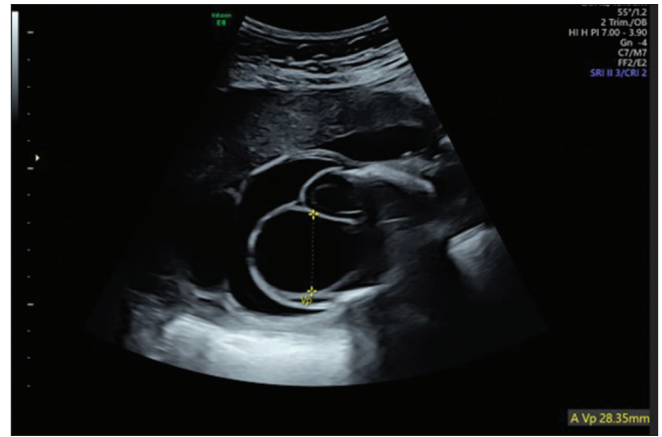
Second-trimester ultrasound of twin B (axial plane), showing posterior atrium measuring 28.35 mm at 25 weeks of gestation, suggesting progressively severe encephalocele
